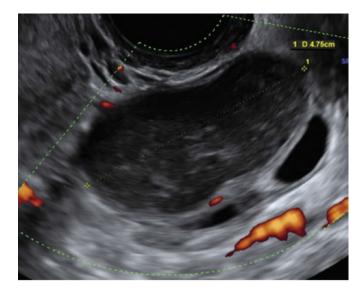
Ultrasonographic appearance of an ovarian endometrioma: a unilocular cyst with irregular ground glass echogenicity due to hyperechoic stripes and no vascularization in the hyperechoic internal tissue, consisting of fibrin densities from the blood content.³
